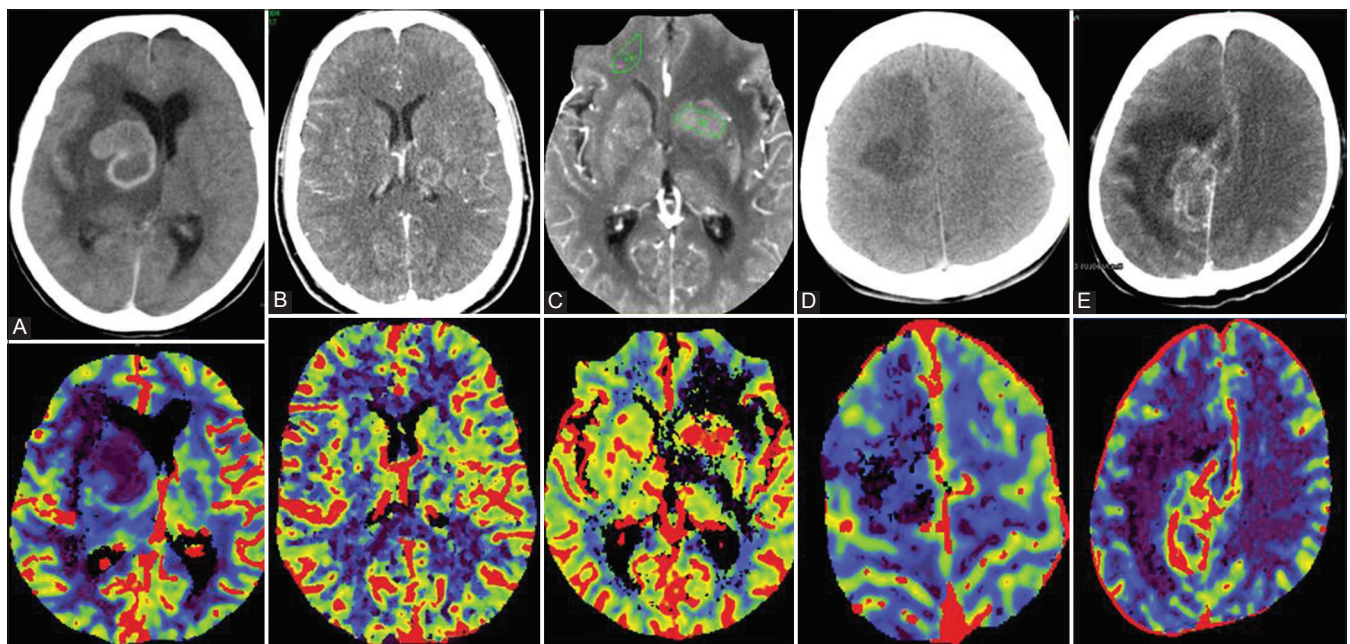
(A-E): Upper column shows post contrast CT and lower column shows colored Perfusion maps. (A) Tuberculoma without treatment in right basal ganglia (low perfusion) (B) Tuberculoma on treatment in left thalamus (high perfusion) (C) Lymphoma in basal ganglia with ROI (high perfusion) (D) Low grade glioma in right frontal lobe (low perfusion) (E) High grade glioma (grade 3) in right parietal lobe (high perfusion)
